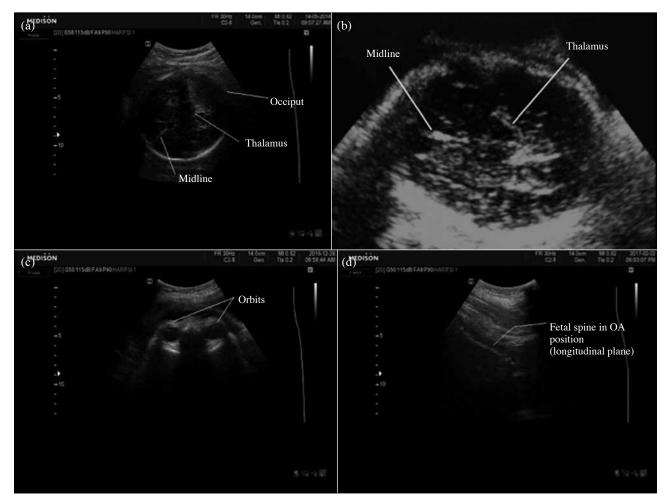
Images of fetal head position obtained by transabdominal ultrasound (transverse plane), with (a) occiput visualised anteriorly in OA position; (b) transversely positioned midline in OT position; (c) anterior pointing orbits in OP position; (d) spine (longitudinal plane) in OA position
